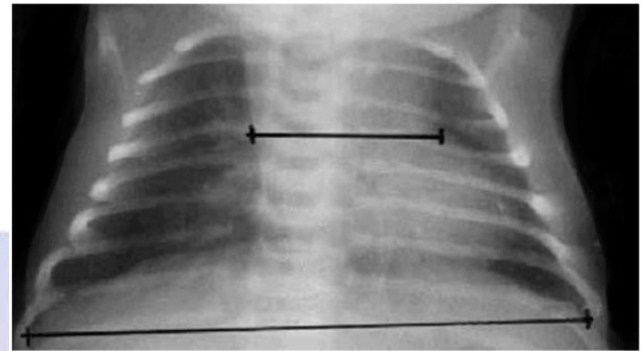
Chest radiograph showing how to measure CT/T Ratio
